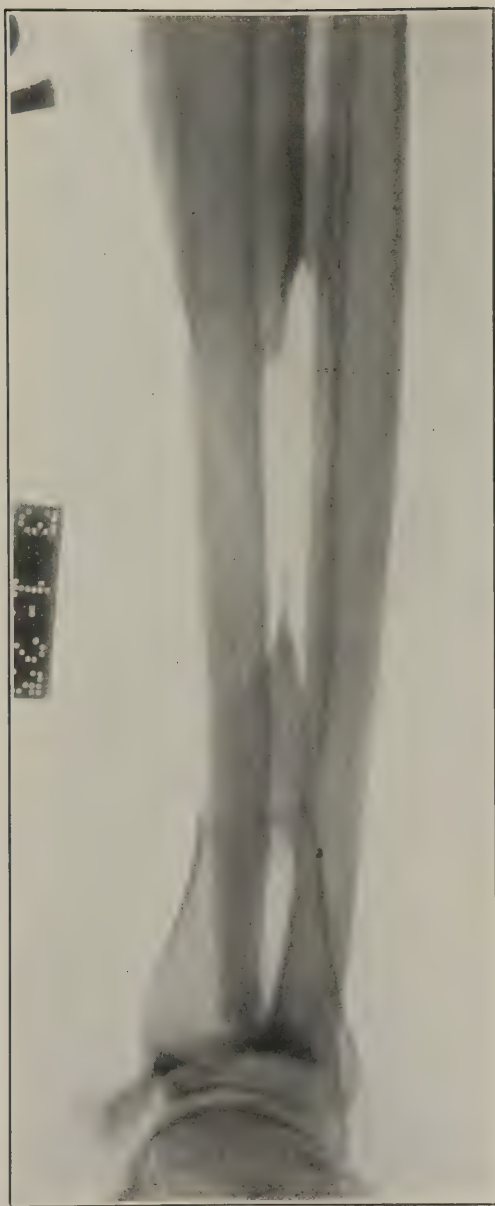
Case 11. Roentgenogram three months after graft showing excellent condition of bone
